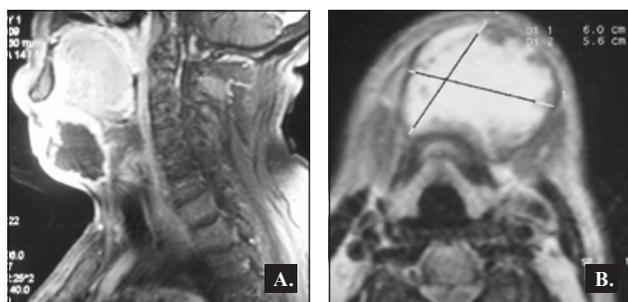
A. Post contrast-enhanced T1-weighted MRI sagittal section of the neck and B. T2-weighted MRI axial section of the neck showing an infected thyroglossal cyst with irregular thickened enhancing wall and internal septa.
